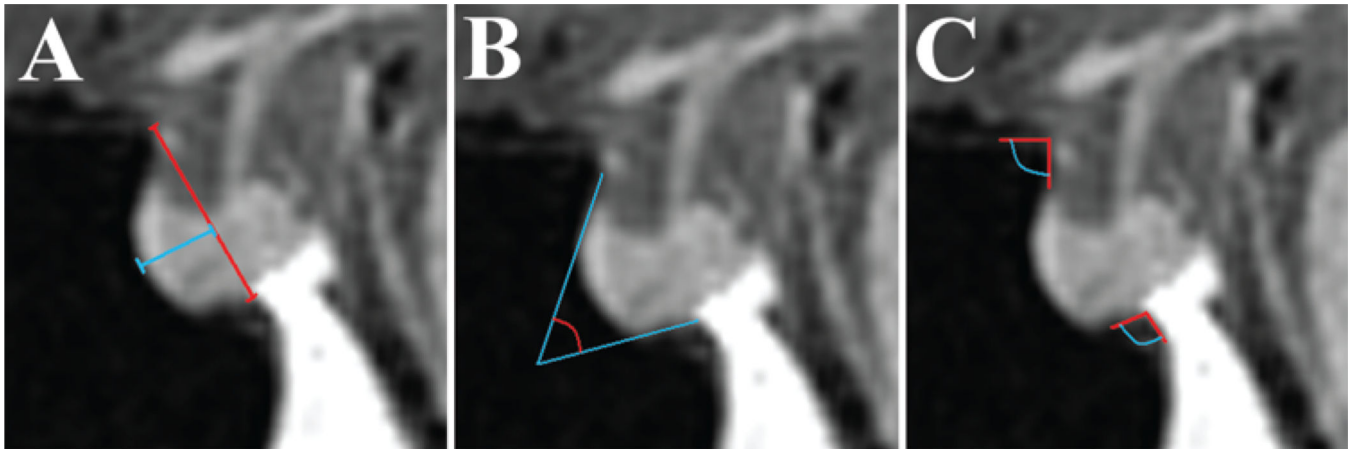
Measurements obtained on midsagittal MR images of the sella turcica. A: The sellar face length was defined by a line from the tuberculum sellae to the sellar-clival angle (*red line*). The prominence of the sella was defined as the maximal length from the sellar face line to the most prominent point on the sellar floor (*blue line*). B: Method of obtaining the sellar angle. C: Depicts angle measurements of the tuberculum sellae angle and sellar-clival angle.
